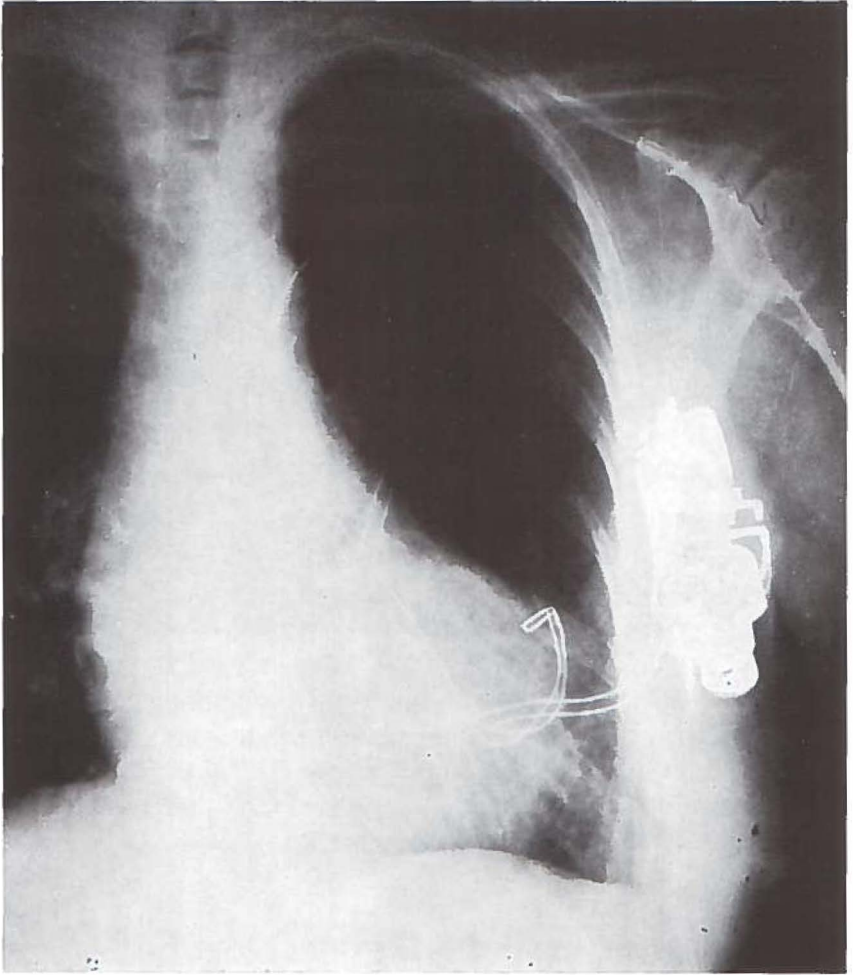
X-ray picture of a stimulation unit with the pacemaker in the subpectoral area and an intramural loop-electrode implanted in the left ventricle.
